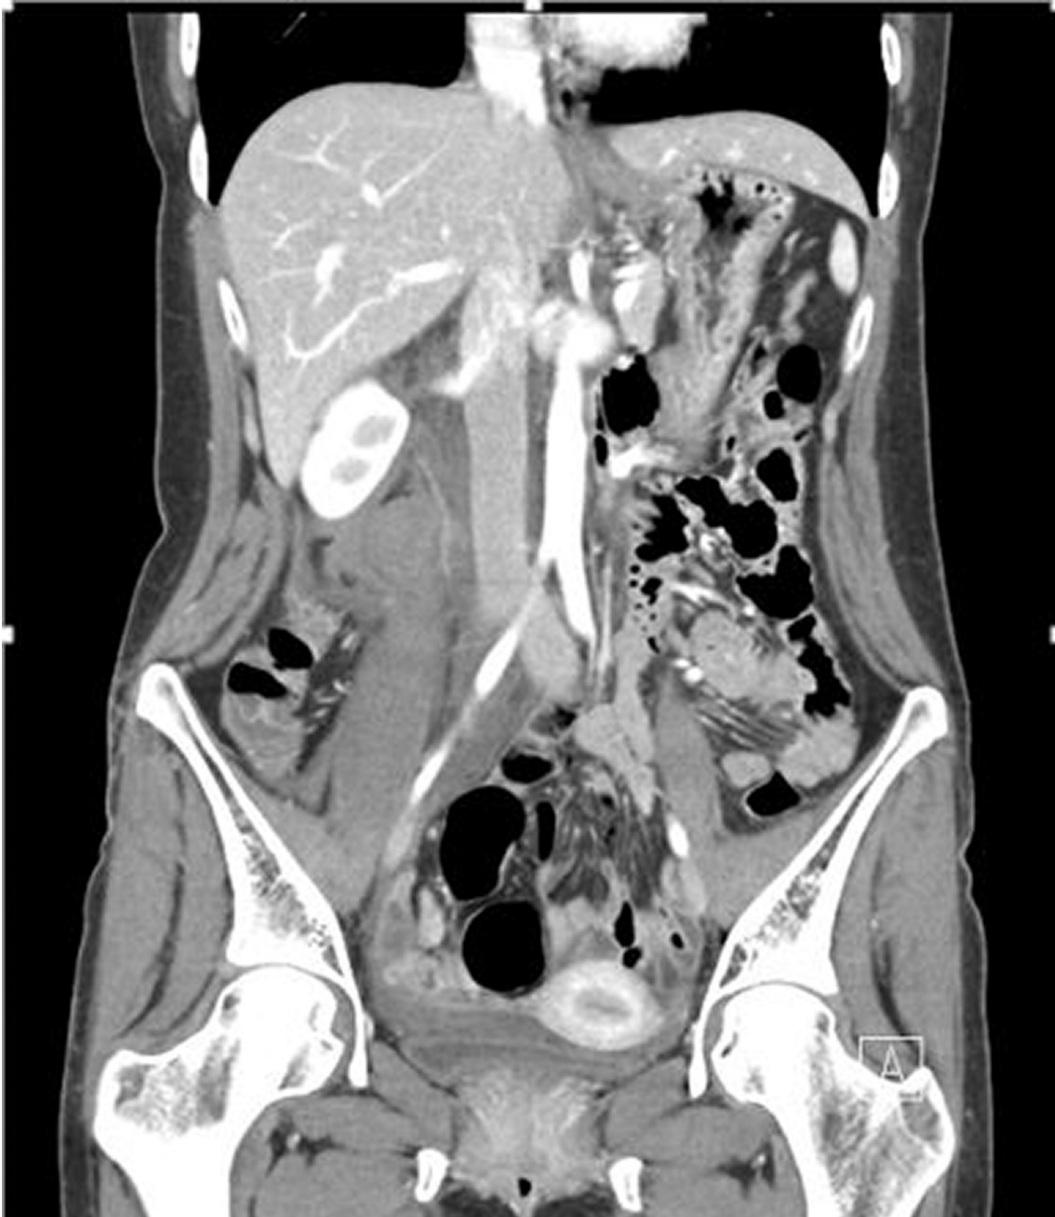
Coronary CT finding. Showing hematoma around the site of the stab wound and right psoas muscle.
